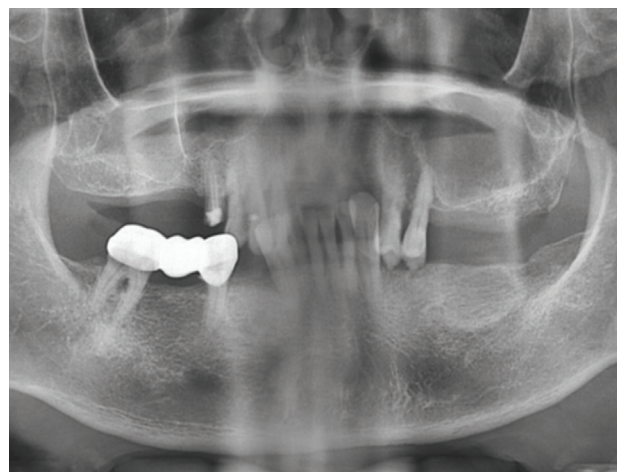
The patient's initial panoramic radiograph film.
